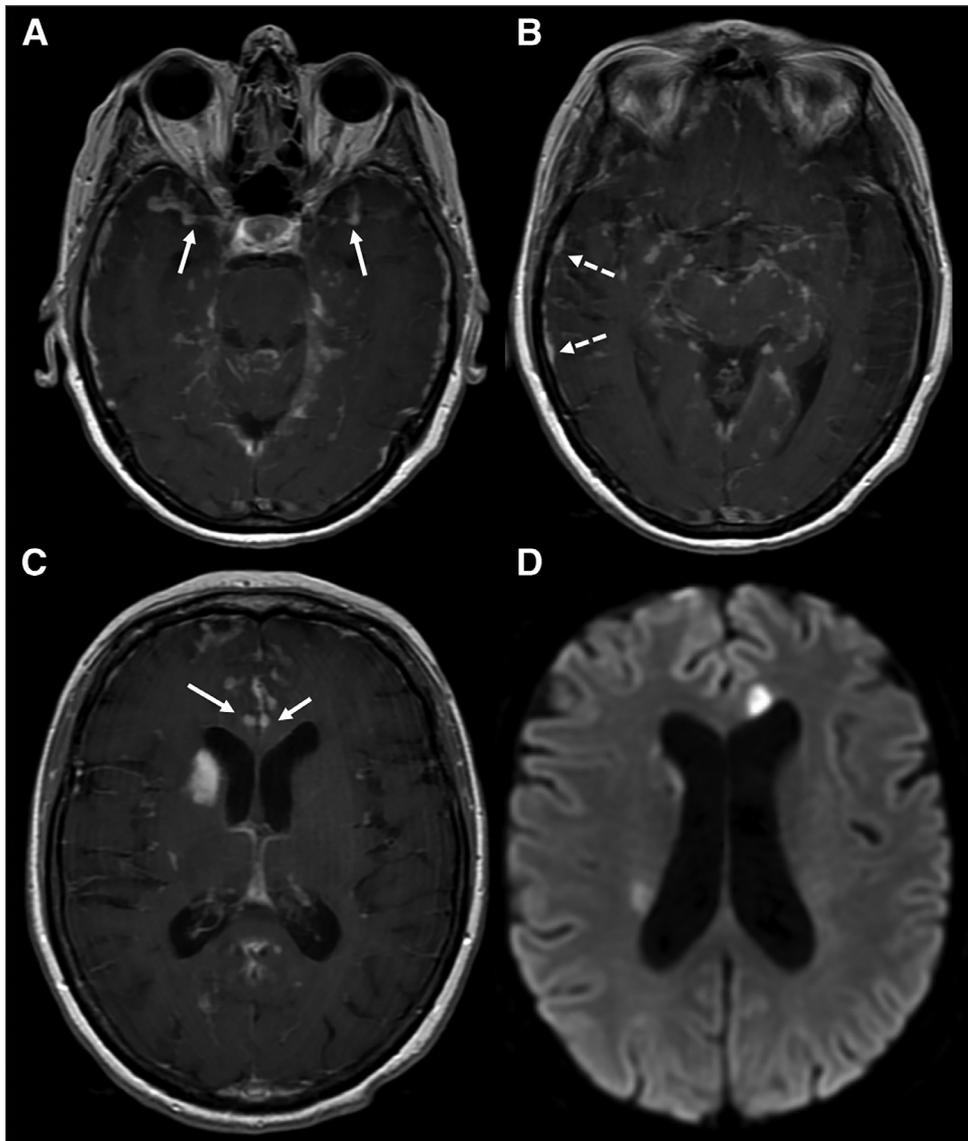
MRI features of patients with cryptococcal meningitis associated strokes.
